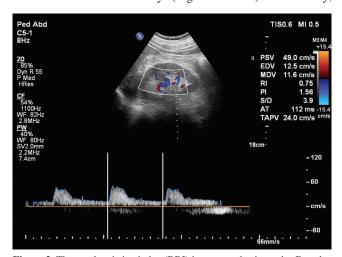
The renal resistive index (RRI) is measured using color Doppler sonography in hypertensive patients with increased thoracic aortic intimamedia thickness. The increased RRI measurement was 0.75.
